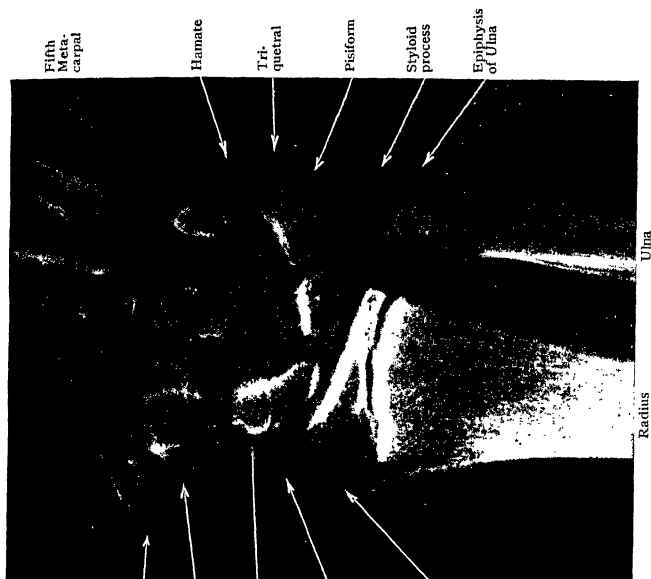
Radiograph of Wrist of girl aged 14, to show the distal epiphyses of Radius and Ulna.
